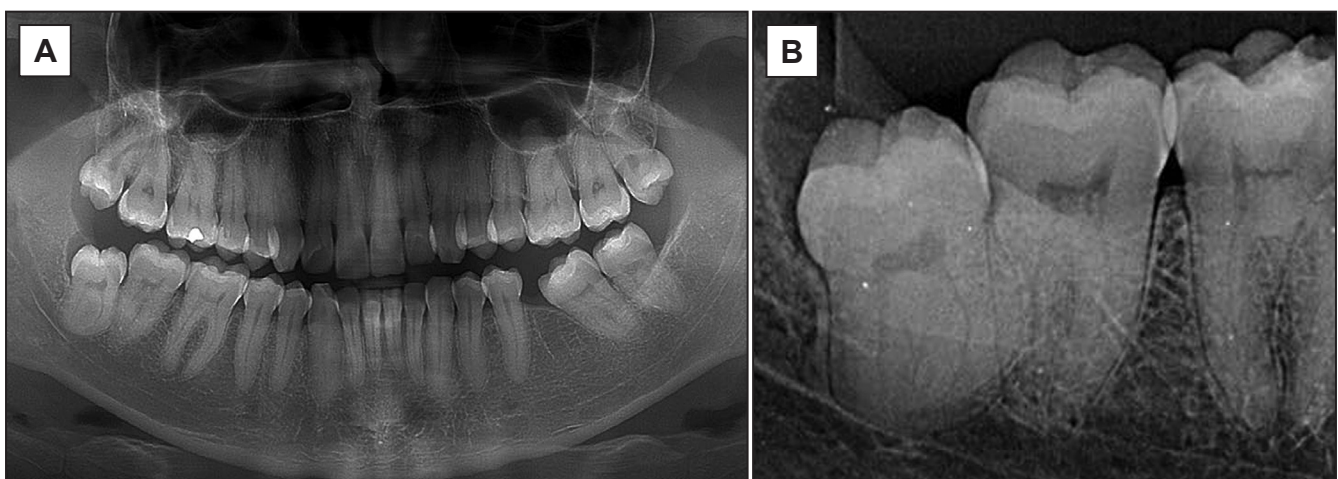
Radiographs requested for third molar extraction: A = preoperative panoramic; B = periapical.
